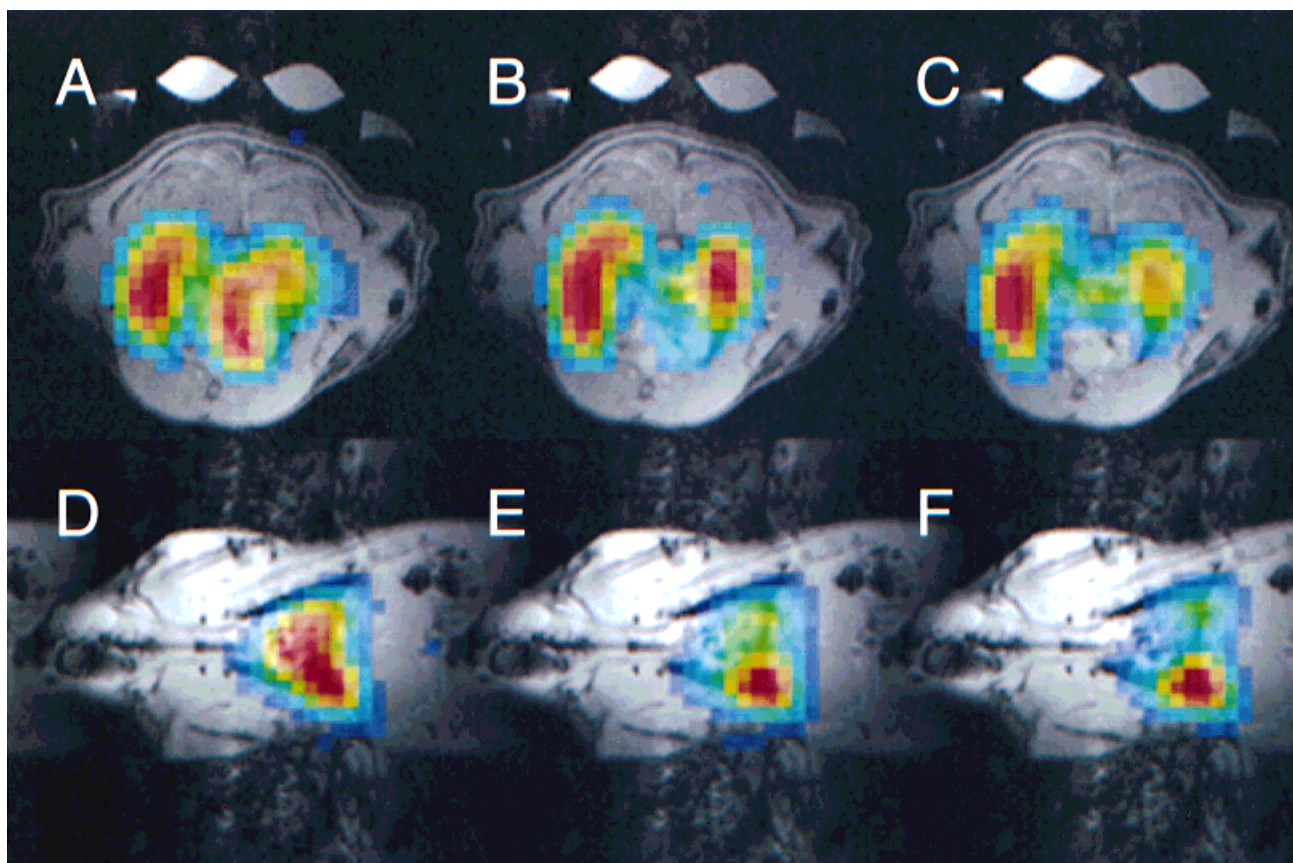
Color overlay of the axial (A–C) and coronal (D–F)  $^{129}\text{Xe}$  images onto the  $^1\text{H}$  images. Images of  $^{129}\text{Xe}$  dissolved in blood (A and D) show xenon in lung vasculature and in the heart ventricle. Images of  $^{129}\text{Xe}$  dissolved in tissue (B and E) show xenon dissolved in the lung parenchyma and in the myocardium. A difference between the gas images (C and F) and the blood images (A and D) can be used to assess lung function in a single MRI study. Images of  $^{129}\text{Xe}$  dissolved in the myocardium can be used to create a map of myocardial perfusion.
